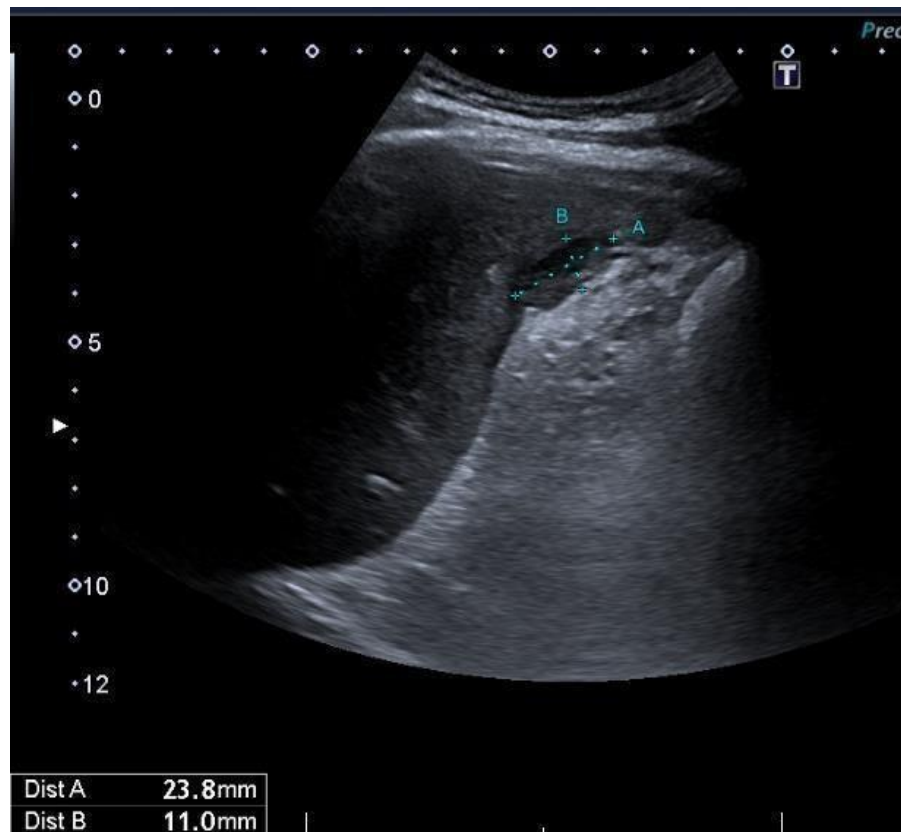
Abdominal ultrasound four weeks after percutaneous drainage showing further reduction of the abscess size.
